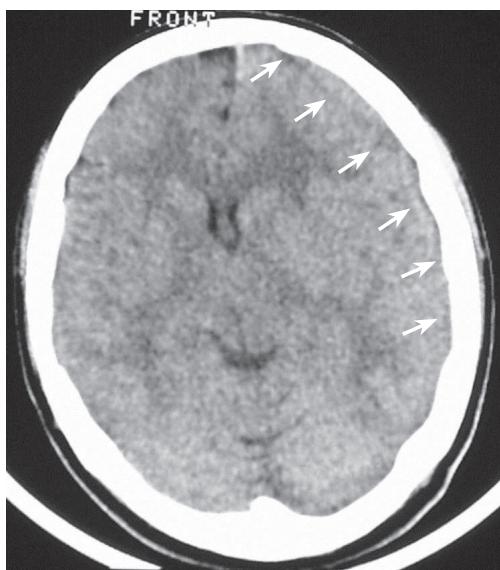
Brain CT Scan without intravenous contrast administration. A left fronto-temporo-parietal subdural haematoma is demonstrated (arrows), with supratentorial midline shift to the right.
